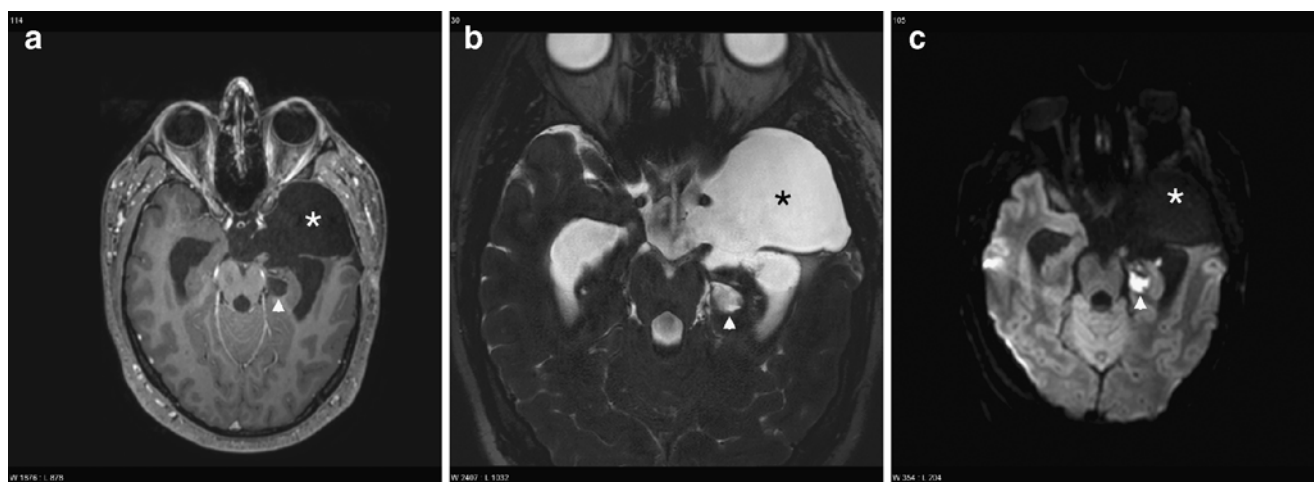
A 38-year-old female with a history of surgery for a large CPA epidermoid with supratentorial extension. Imaging performed in the follow-up status of the patient. a Axial post-gadolinium 3D GRE T1-weighted image. There is a large hypointense region in the left temporal region probably a region of tissue loss as a postoperative sequel (*asterisk*). There is another rounded hypointense region deep in the left temporal lobe (*arrowhead*). b Axial 2-mm-thick MPR of a 0.4-mm 3D TSE T2-weighted sequence. Large hyperintense region in the left temporal region, probably a region of tissue loss as a postoperative
